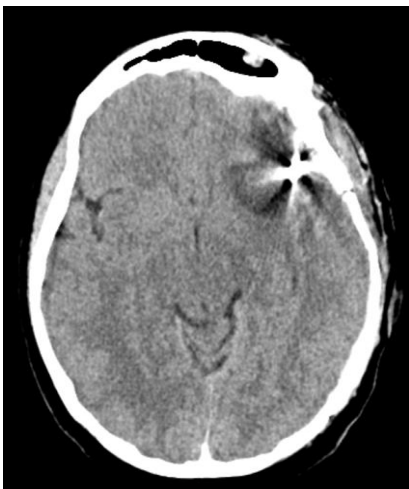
Control cerebral CT-scan
